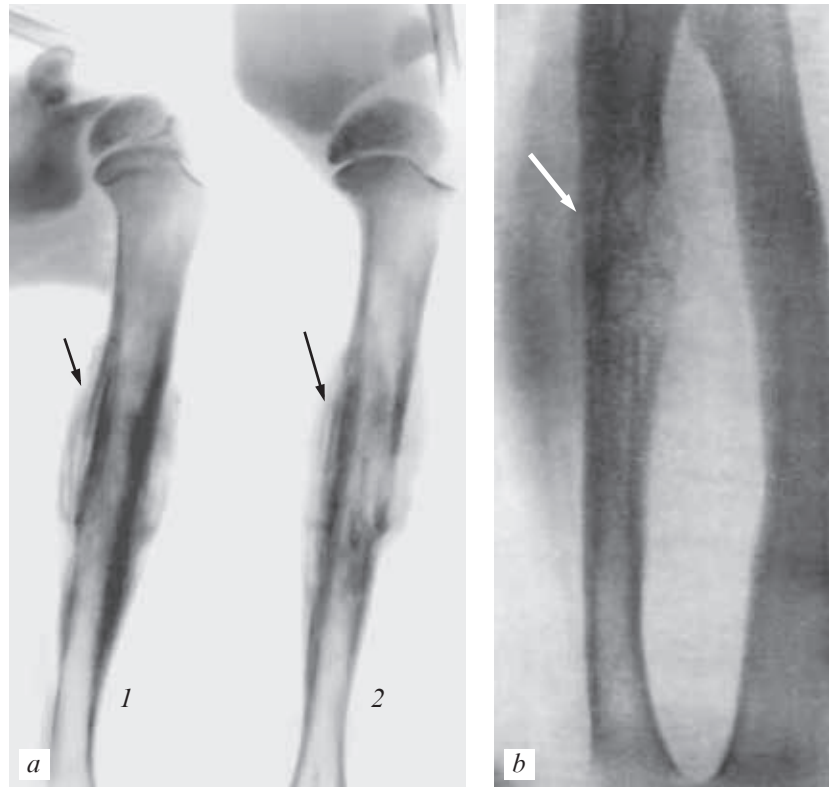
X-ray: *a* — the humerus and the shoulder joint (*1* — straight; *2* — axial projections), *b* — of the ulna at Ewing's tumor: multilayered periosteal reaction is noted throughout the shaft
